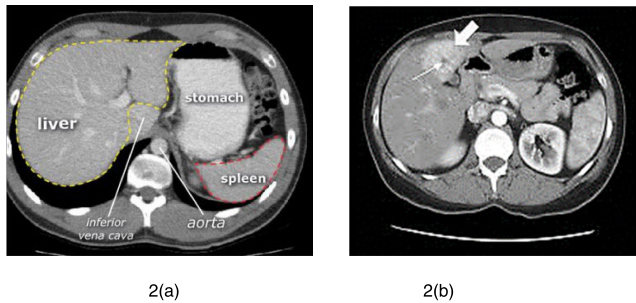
(a) Normal Abdominal CT scan [20] (b) Liver Lesion Image [21].
